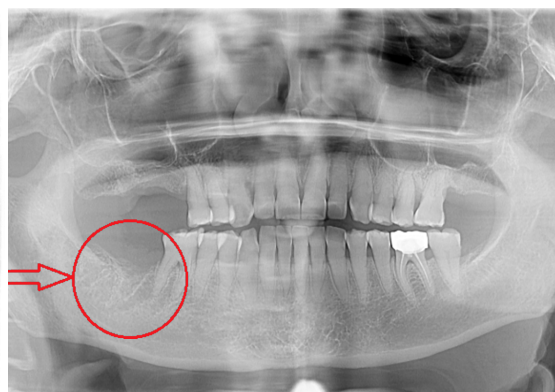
OPG showing little ossification at a previous right mandibular extraction site. OPG: Orthopantomogram.
